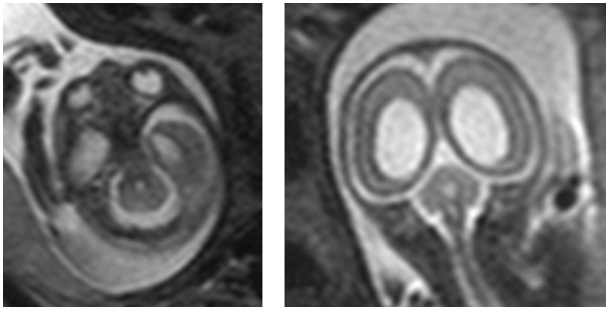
T2-weighted images, gestational age 23 weeks: ventriculomegaly with cerebellar hypoplasia, agenesis of the vermis and fusion of the cerebellar hemispheres (rhombencephalosynapsis), shown in axial (left) and coronal (right) plane.
